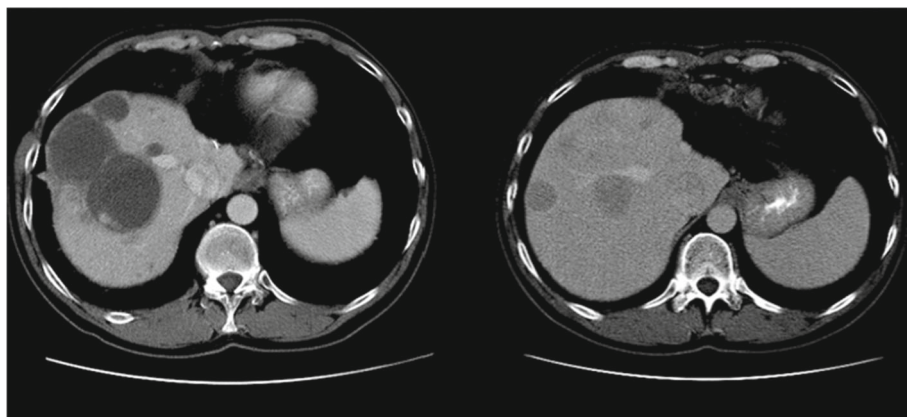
As it can be seen, contrast enhanced liver CT image can have high background noise
